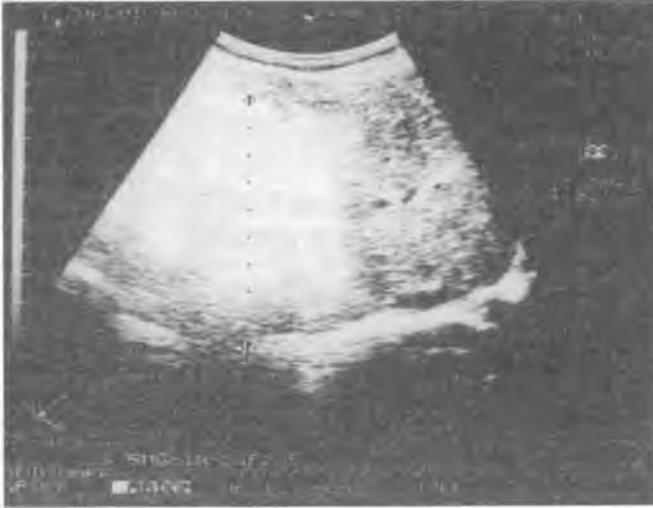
Sonogram reveals solid mass in right epigastrium of a 60-year-old woman
